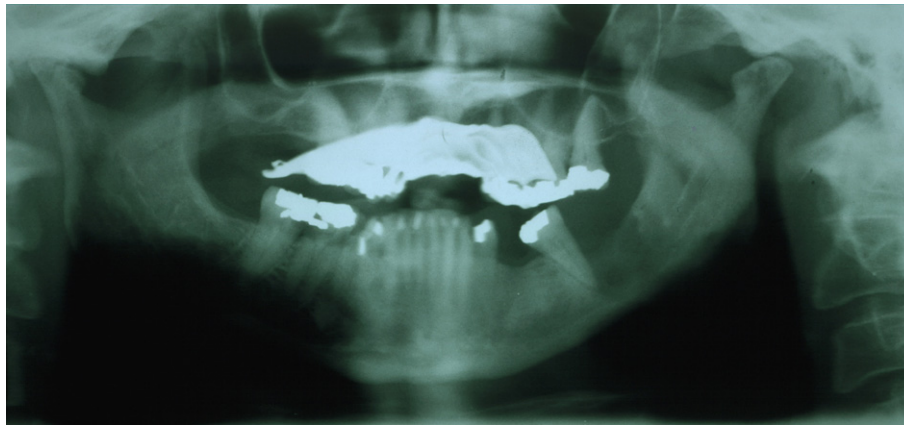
A panoramic radiograph reveals a poorly circumscribed radiolucent lesion in the left posterior mandible.
